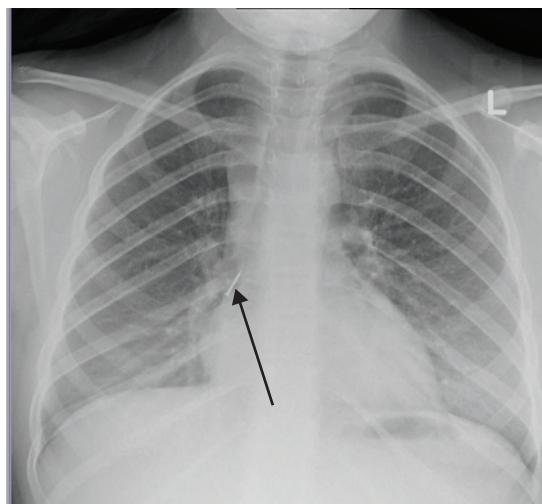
Chest X-ray showing a pin (arrow) in the right main bronchus.
